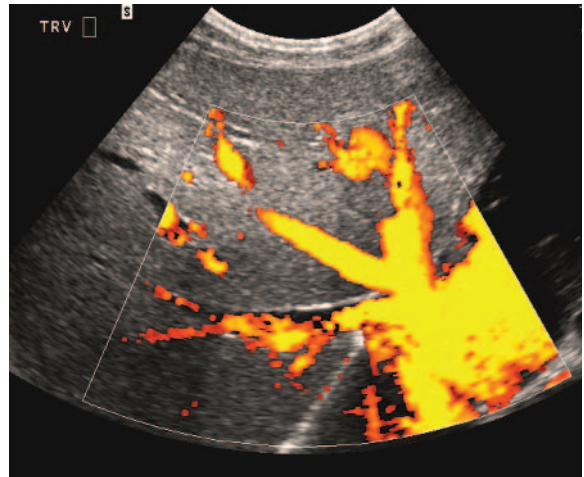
Power Doppler of the hepatic vein confluence. We have lost the directional information, but flow is demonstrated in all parts of the vessel—even those perpendicular to the beam.
